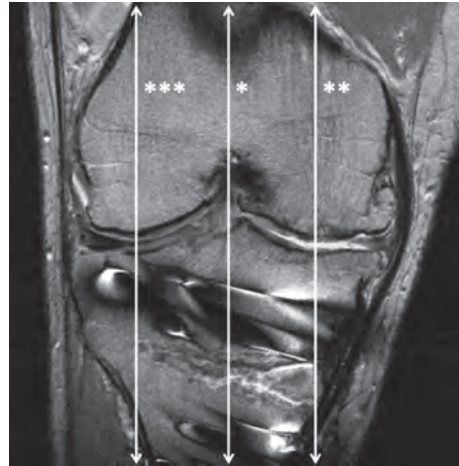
Post-operative MRI, 2 years after an opening-wedge high tibial osteotomy. Sagittal images were identified from the axial images at the joint line for the mid-sagittal slice (single asterisk), the mid-medial tibial plateau (double asterisks) and the mid-lateral tibial plateau (triple asterisks).
